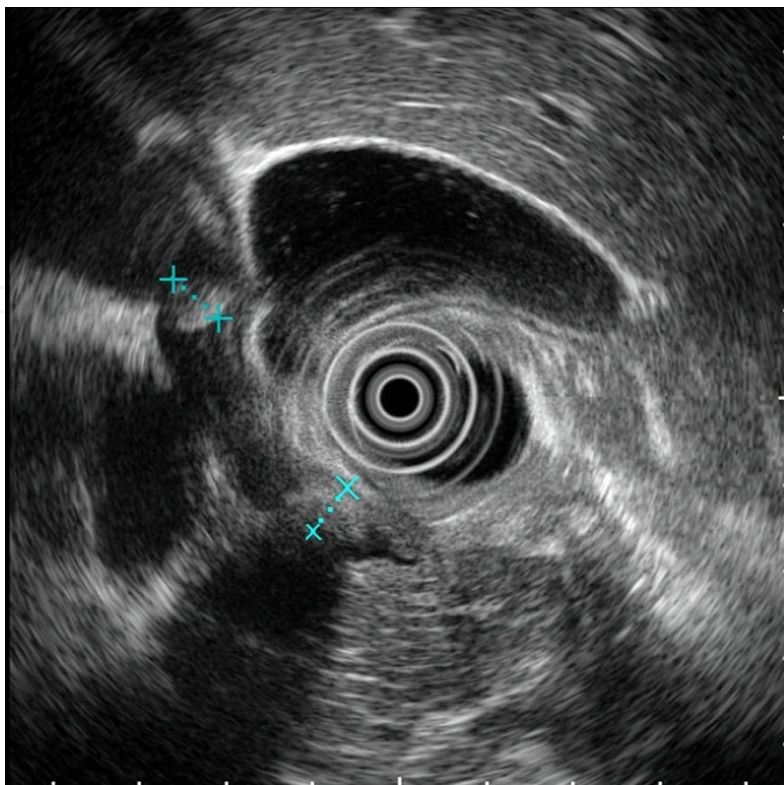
Endoscopic Ultrasound Image of Two Stones in Common Bile Duct
